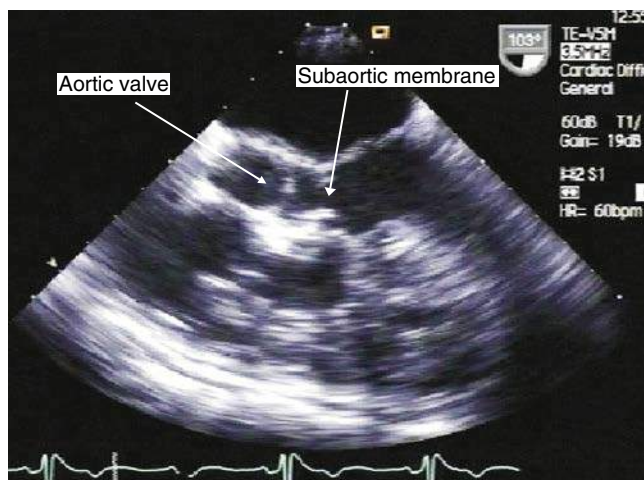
Transesophageal echocardiogram from patient with discrete subaortic stenosis.
